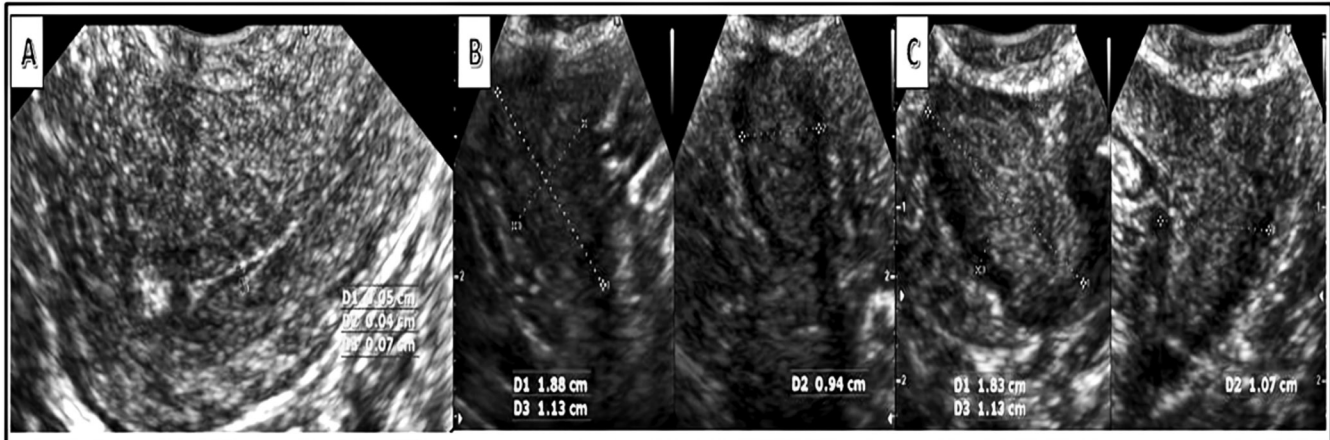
Transvaginal ultrasound images. Transvaginal ultrasound revealed a small-sized uterus with linear endometrium (A). The right (B) and left (C) ovaries were small with no antral follicles seen.
